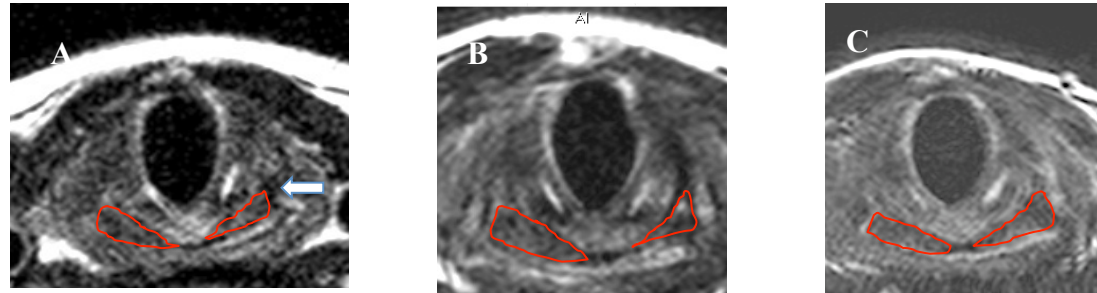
Patient-1 T2-MRI PCA bulk on axial plane at: baseline (A); 6- (B); and 12-months (C) post-selective reinnervation. The arrow shows the paralysed side.
